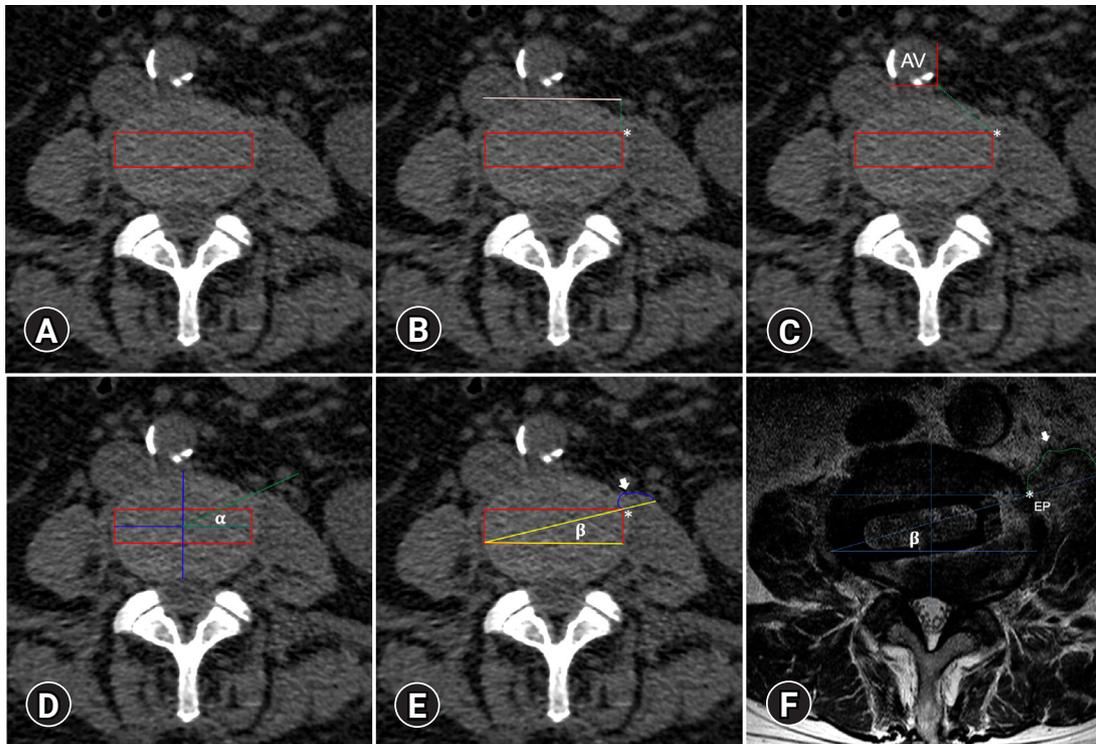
Proposed CT-based preoperative assessment for planning an oblique trajectory. (A) The middle third is shown in red. (B) Distance between the anterior vertebral line (white line) and the entry point. (C) Distance between the anterior vessel (AV) and the entry point (green dotted line). (D) The α and (E) β trajectories. The white arrow pointed to the psoas cross-sectional area ventral to the β trajectory potentially retracted. (F) An example showing a postoperative axial view of MRI showing the cage's final location under the β trajectory. Entry point (*).
